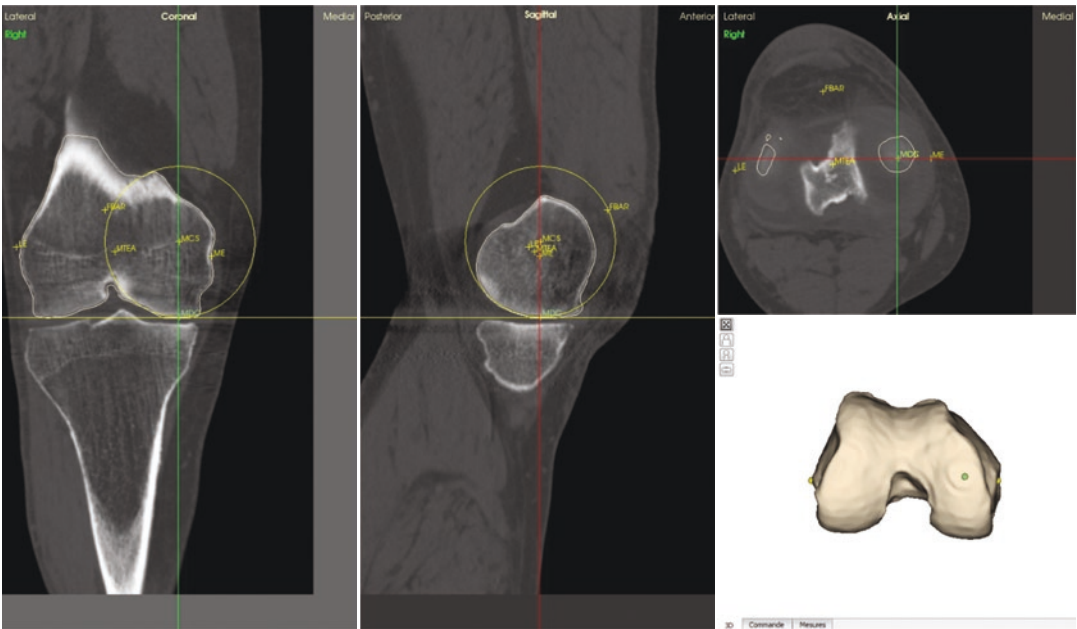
CT slices of a patient's knee and a sphere is placed over the medial condyle of the femur
